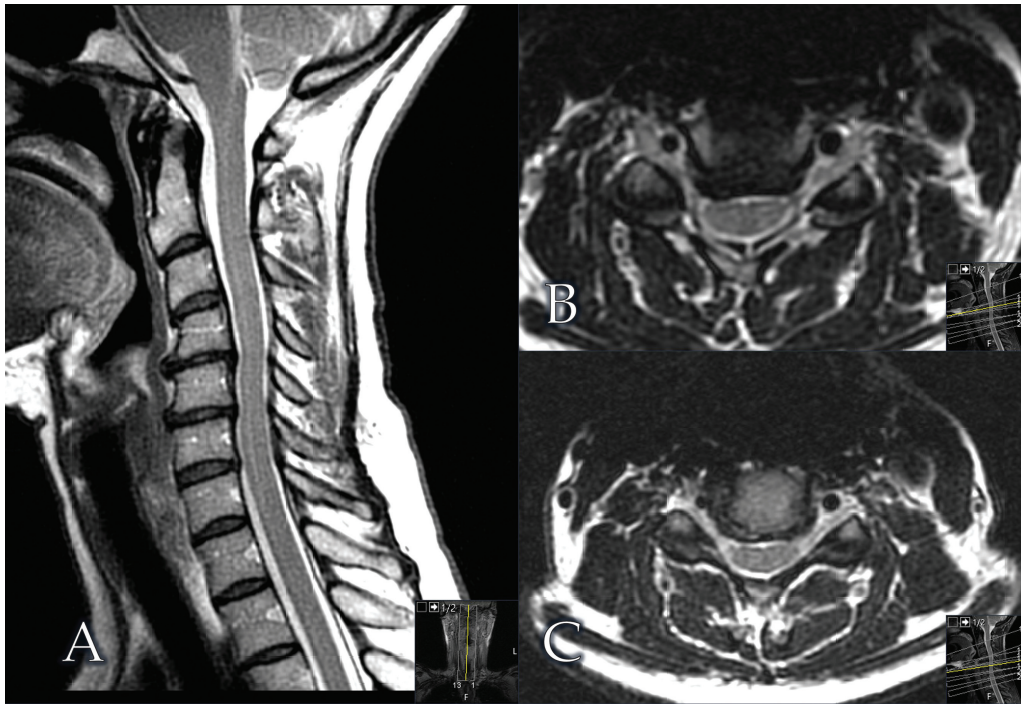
Magnetic resonance imaging of patient 2. (A) Sagittal image showing disc height loss with degenerative change at C4-5 and C5-6. (B) C4-5 axial and (C) C5-6 axial imaging showing right-sided foraminal stenosis.
